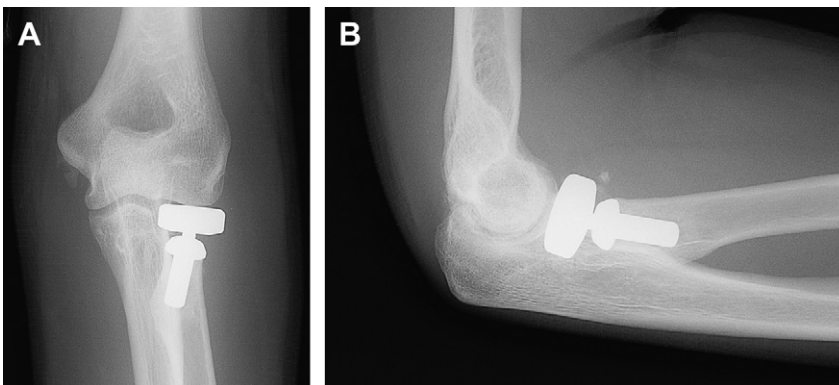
(A) Anteroposterior and (B) lateral radiographs after metallic radial head arthroplasty.
